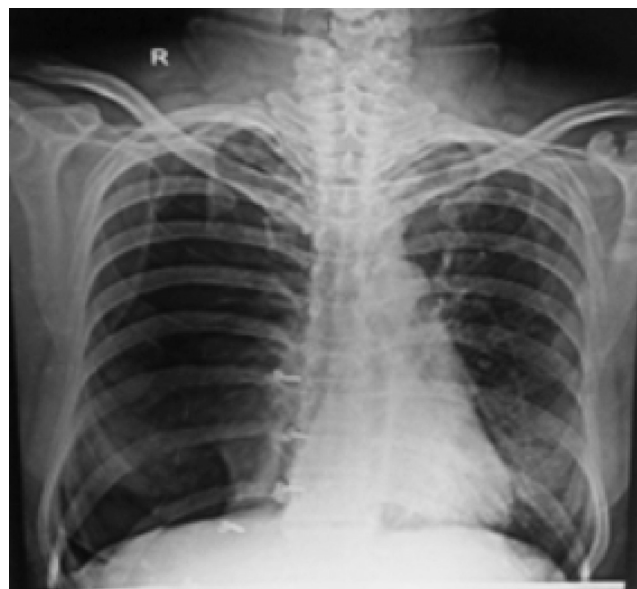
Chest radiograph (postero-anterior view) taken with abdominal shield obtained during the first episode showing right-sided pneumothorax.
